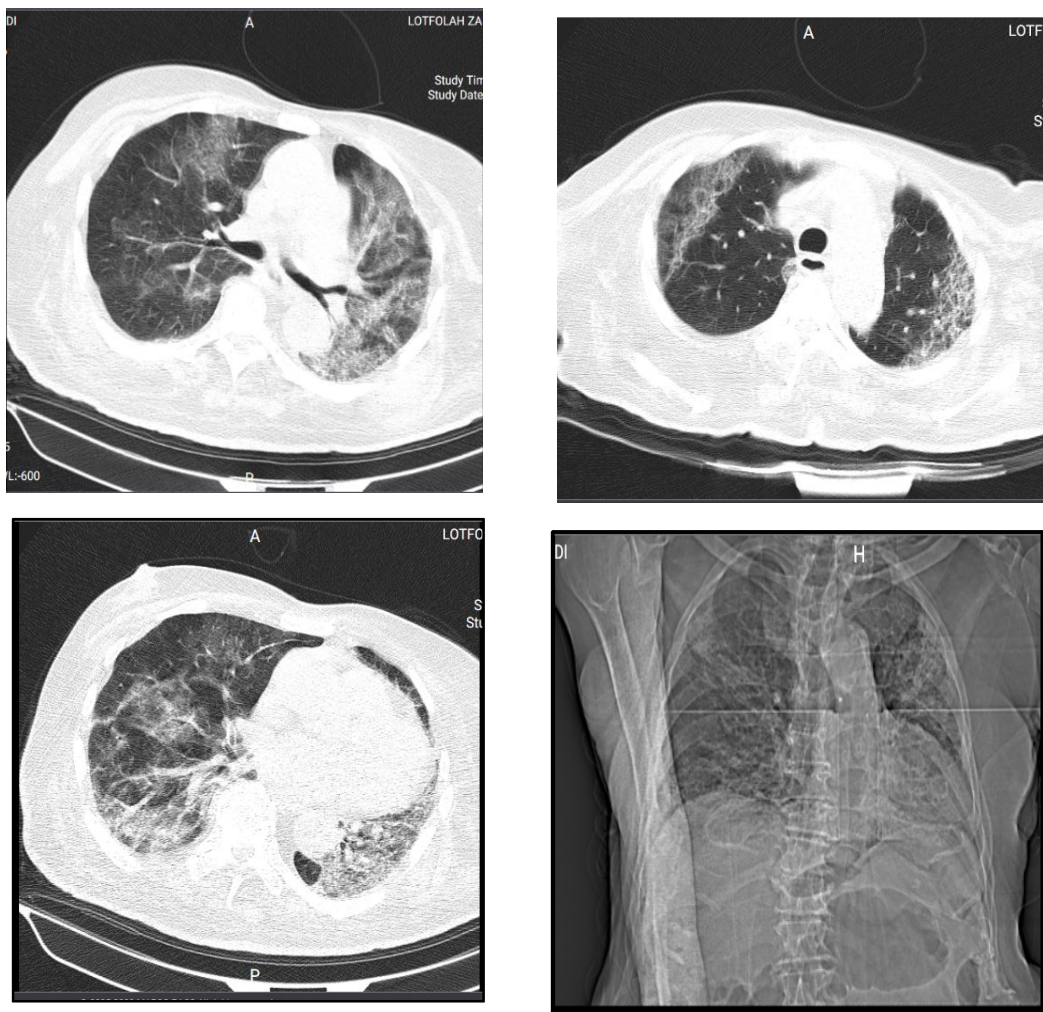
Chest CT scan showing bilateral ground-glass opacities with consolidation and mediastinal lymphadenopathies in aortopulmonary window
